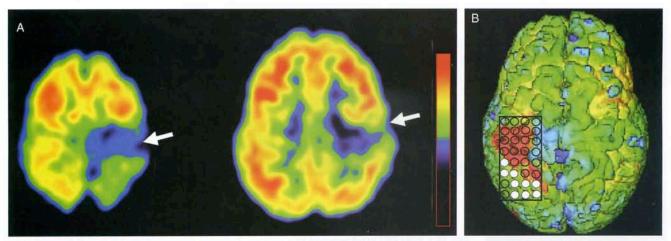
A. FDG PET showing a well-defined area of hypometabolism in the superior parietal cortex of a 7.5-year-old girl with intractable seizures that started at 2 years of age. MRI was unremarkable but the abrupt decrease of cortical metabolism on PET suggested a lesion.
